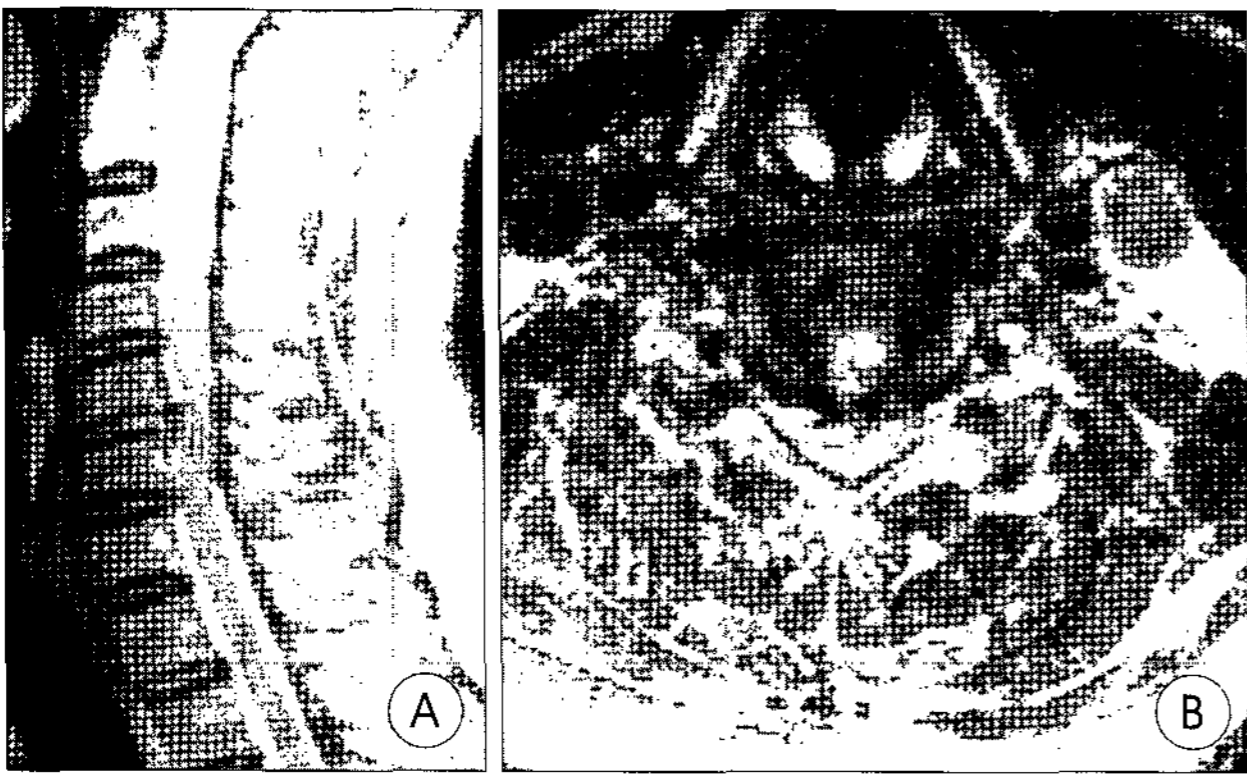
Case 1. Preoperative T2-weighted sagittal (A) and axial (B) magnetic resonance images revealing a large C5-C6 disc herniation, compressing the right side of the spinal cord.
